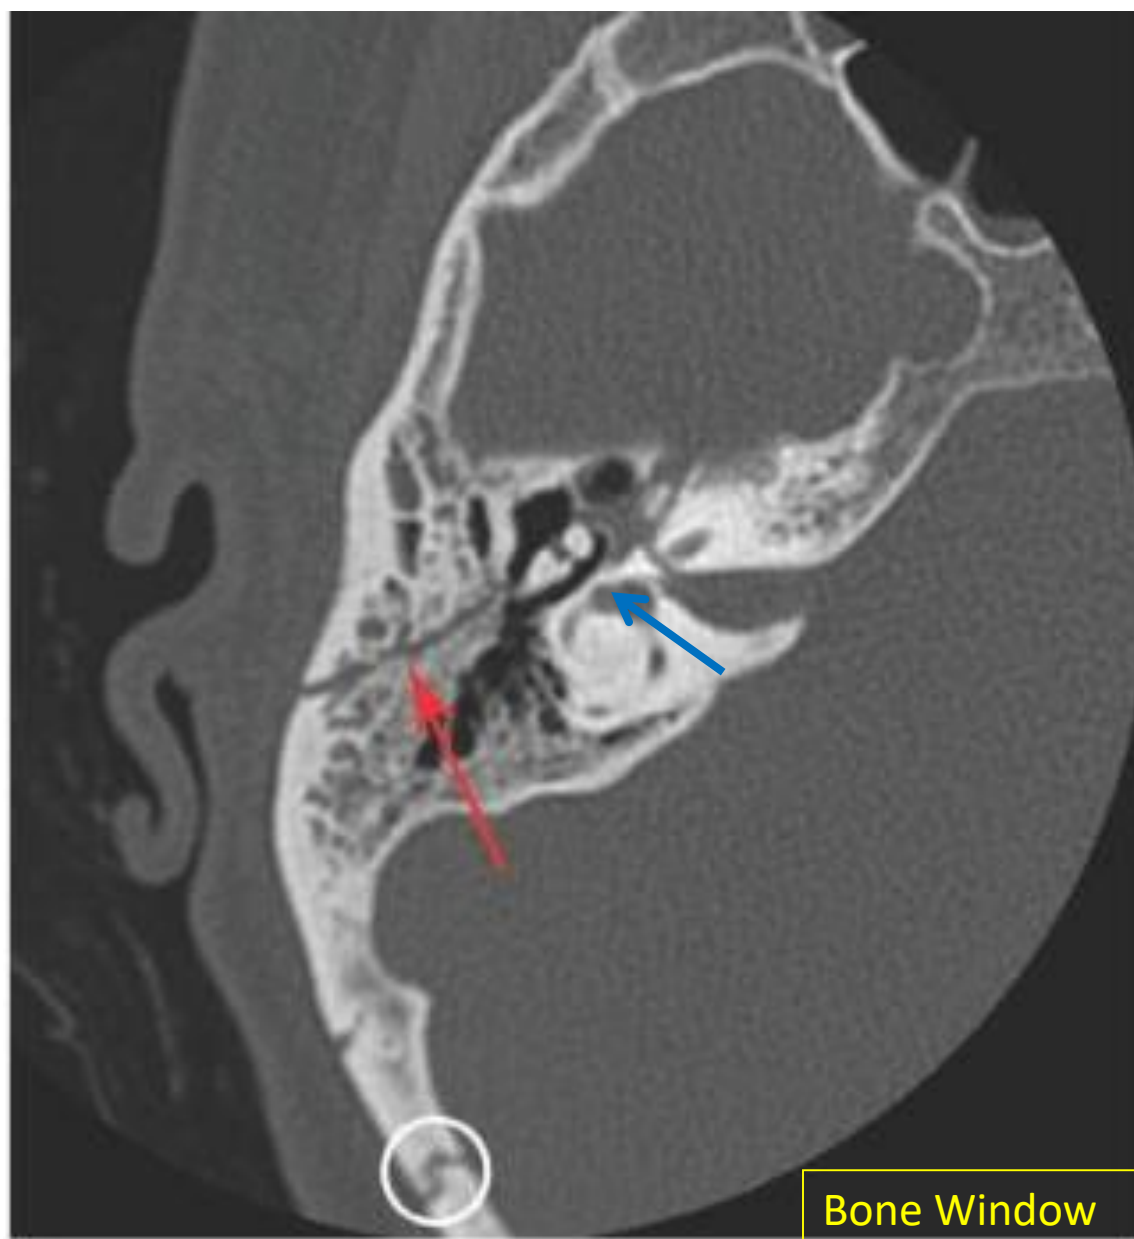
Longitudinal Temporal Bone Fracture. Axial CT image shows a right longitudinal temporal bone fracture (*arrow*) with associated incudomalleal dislocation. Diastasis of the right lambdoid suture (*circle*) is also present.
